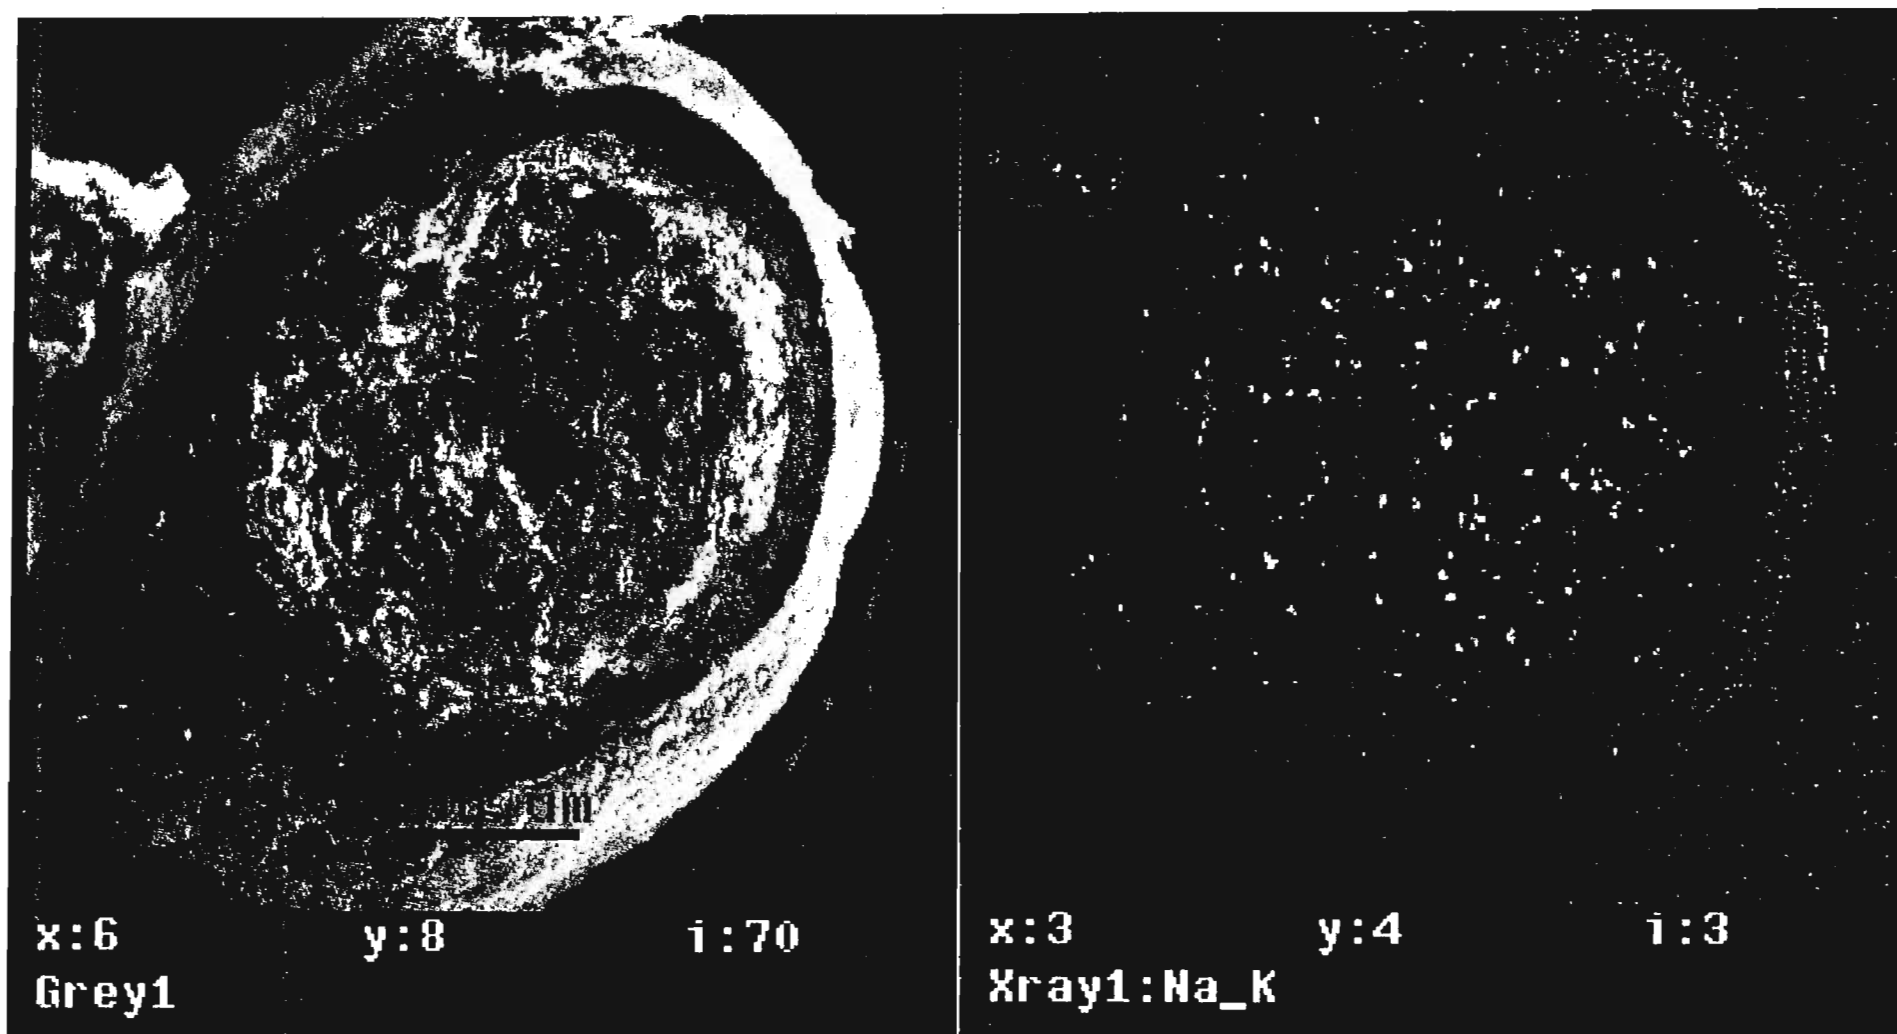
X-ray Map of a Cross-section of a Naproxen Sodium-Cetostearyl Alcohol Microsphere (Batch NC81)
